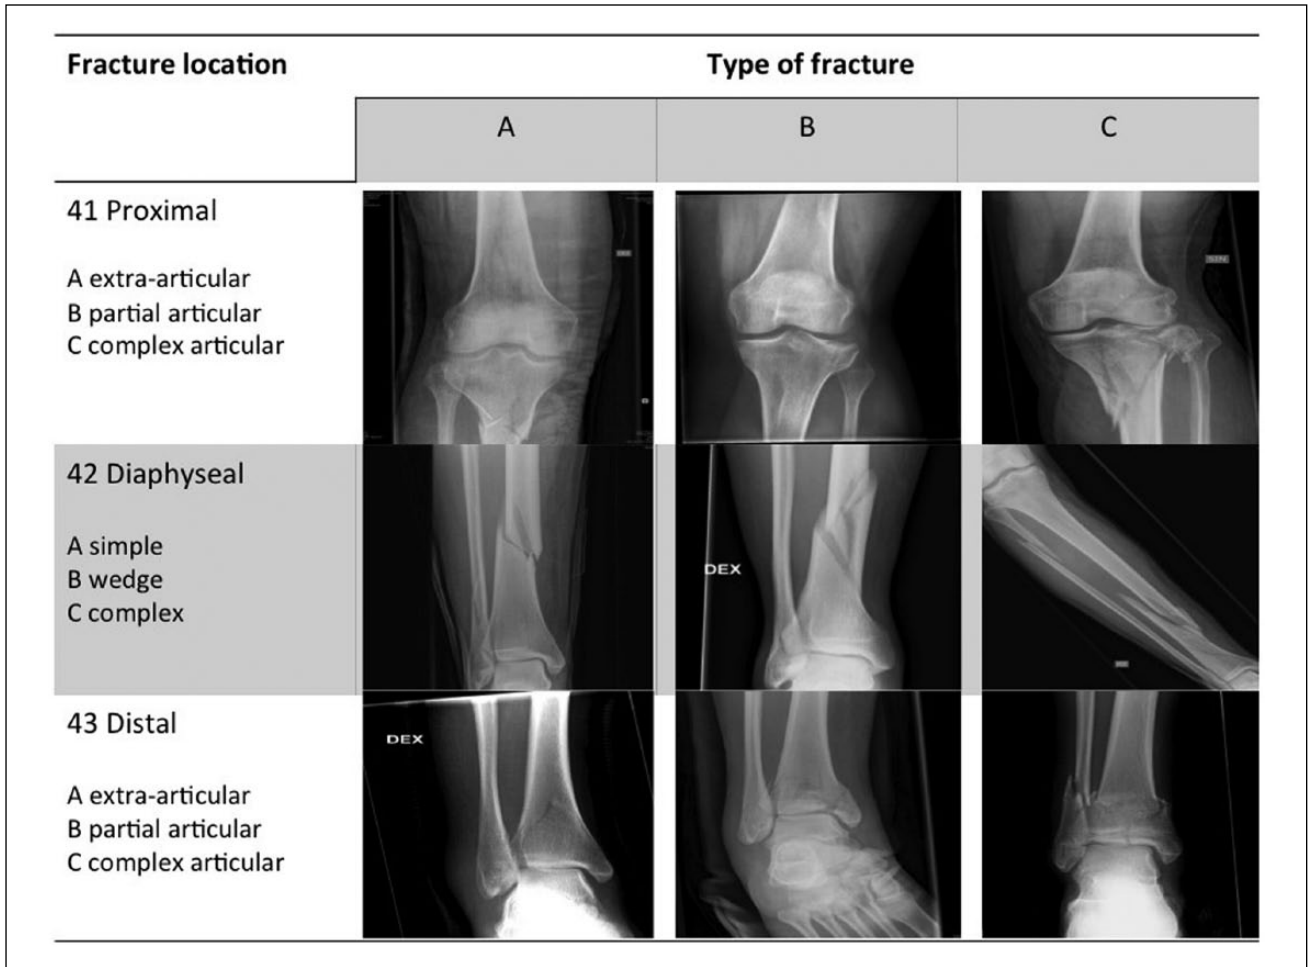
AO-fracture classification in tibia presented by example plain X-rays observed in study patients.
